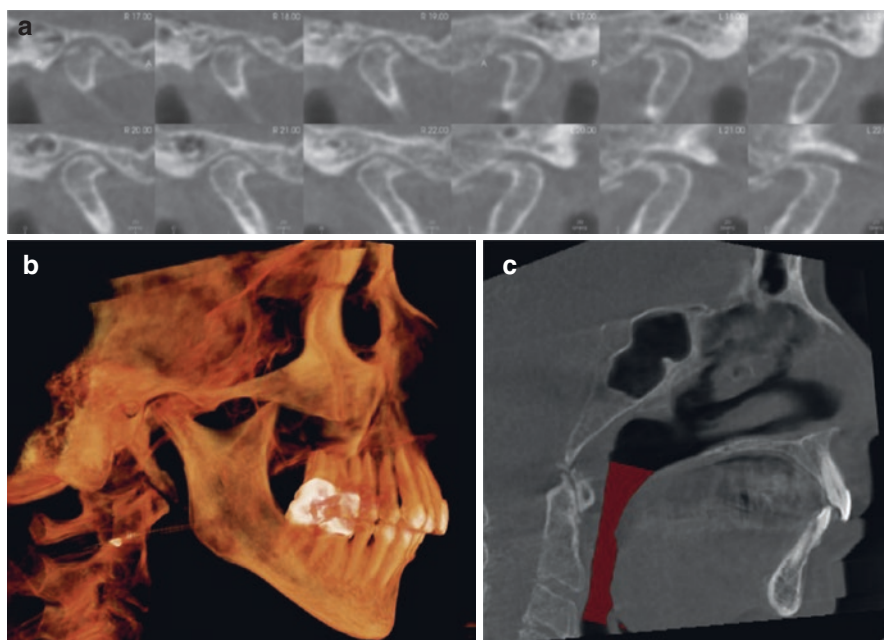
(a) TMJ cross sections show bilateral reduction of condylar height due to degenerative joint disease. The condyles are seated in the fossae. (b) With the reduction of condylar height and seating of the condyles, the mandible has rotated posteriorly and superiorly, resulting in steep mandibular planes and more posteriorly positioned mandible. (c) This has resulted in narrowing of the oropharyngeal airway due to posterior repositioning of the tongue and floor of the mouth. The hyoid bone is very low due to this repositioning of the floor of the mouth to the point that it was not included in the CBCT field of view
